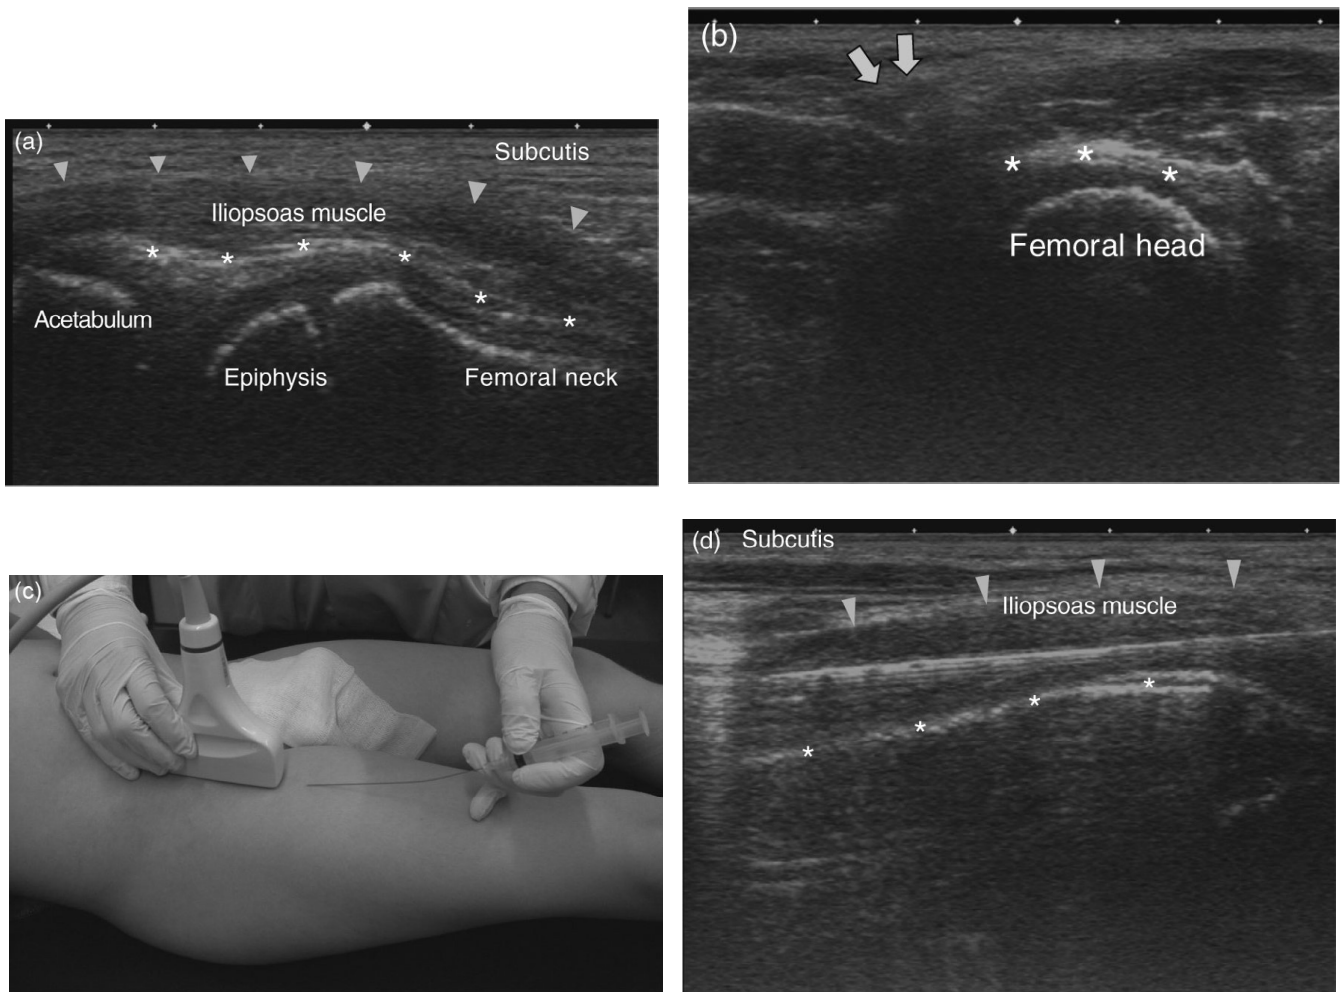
Injection of the iliopsoas muscle (a) Longitudinal ultrasound view of the hip joint; the iliopsoas muscle lies directly on the joint capsule (*); the triangles mark the border to the subcutis. (b) Transverse ultrasound view of the iliopsoas at the level of the femoral head; the arrows marks the femoral vessels. During real-time imaging, pulsation can be followed. (c) Clinical picture showing needle and probe during injection. (d) Ultrasound showing the needle placed in the iliopsoas muscle; the triangles mark the border of the iliopsoas muscle; the injection needle is identified as a hyperechoic white line; in this case an artifact is visible as there are further white lines behind the needle itself (repeating echos); *corresponding to the OS ilium.
